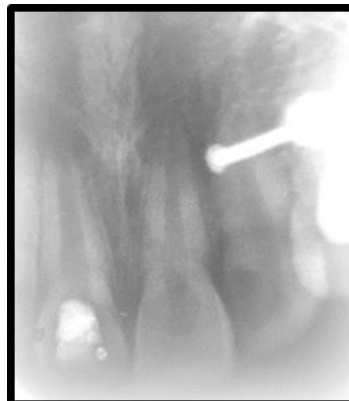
Follow up after 1 month showing progressive healing of periapical region.
